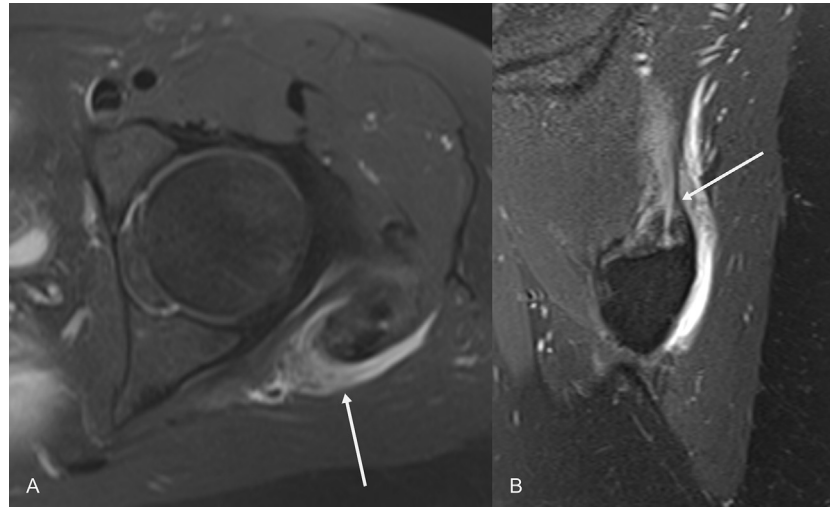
Axial (A) and sagittal (B) PD fluid sensitive MRI. There is thickening and heterogeneity of the left gluteus medius tendon at its insertion onto the greater trochanter (white arrows).
